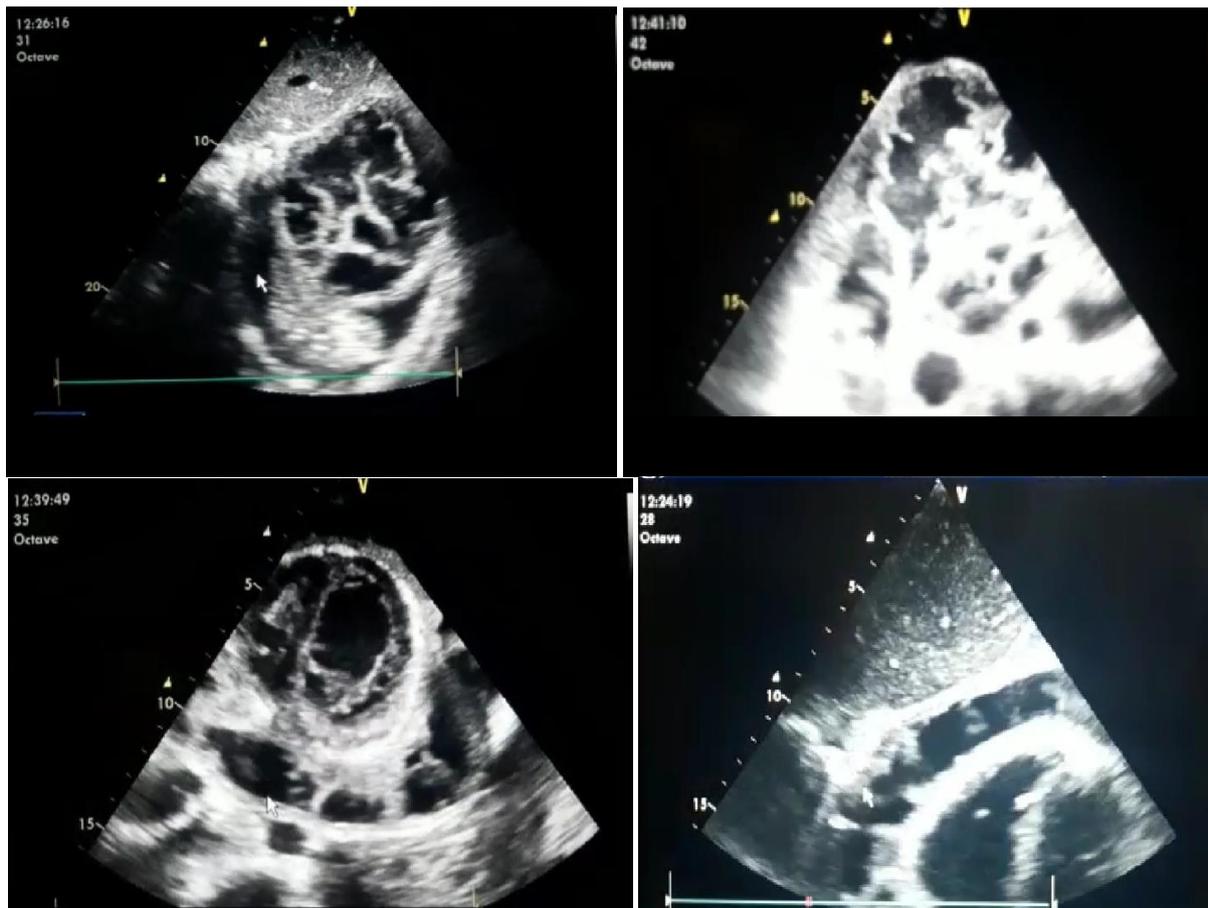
2D transthoracic echocardiogram in the apical 4-chamber view of the heart and modified apical views revealed a large circumferential pericardial effusion, with intrapericardial adhesions (fibrin strands) partially attached and floating between the visceral and parietal pericardium
